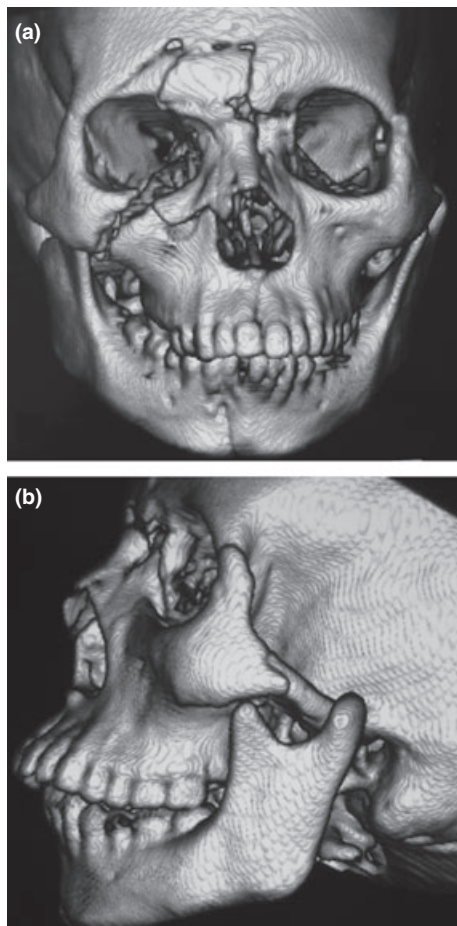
Three-dimensional computed tomography (CT) features of superolateral dislocation of intact mandibular condyle. (a) CT shows a panfacial fracture. (b) CT demonstrated a superolateral dislocation of the intact left condyle.
